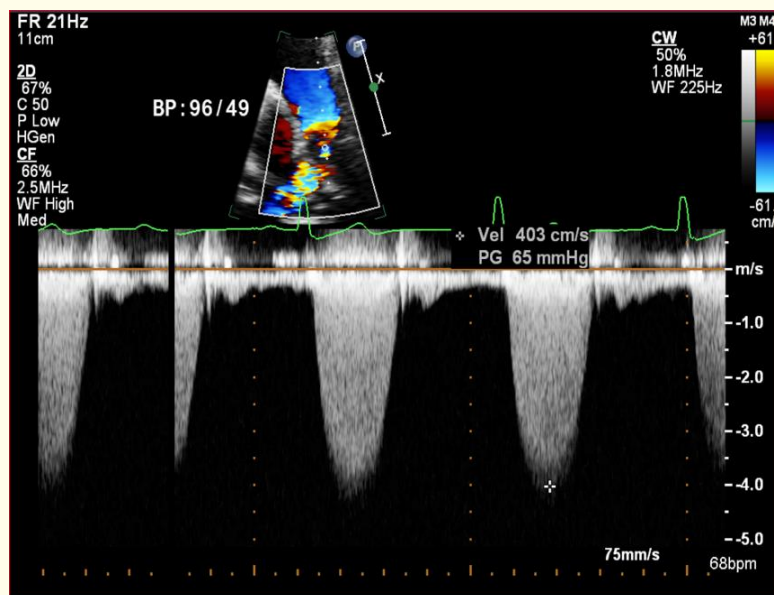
A 2 dimension (2D) guided continuous wave Doppler image from PSAX at level of right ventricular outflow tract (RVOT) shows a maximum velocity of 4.03 m/s, and a pressure gradient of 65 mmHg represented sever supravalvular pulmonic stenosis.
